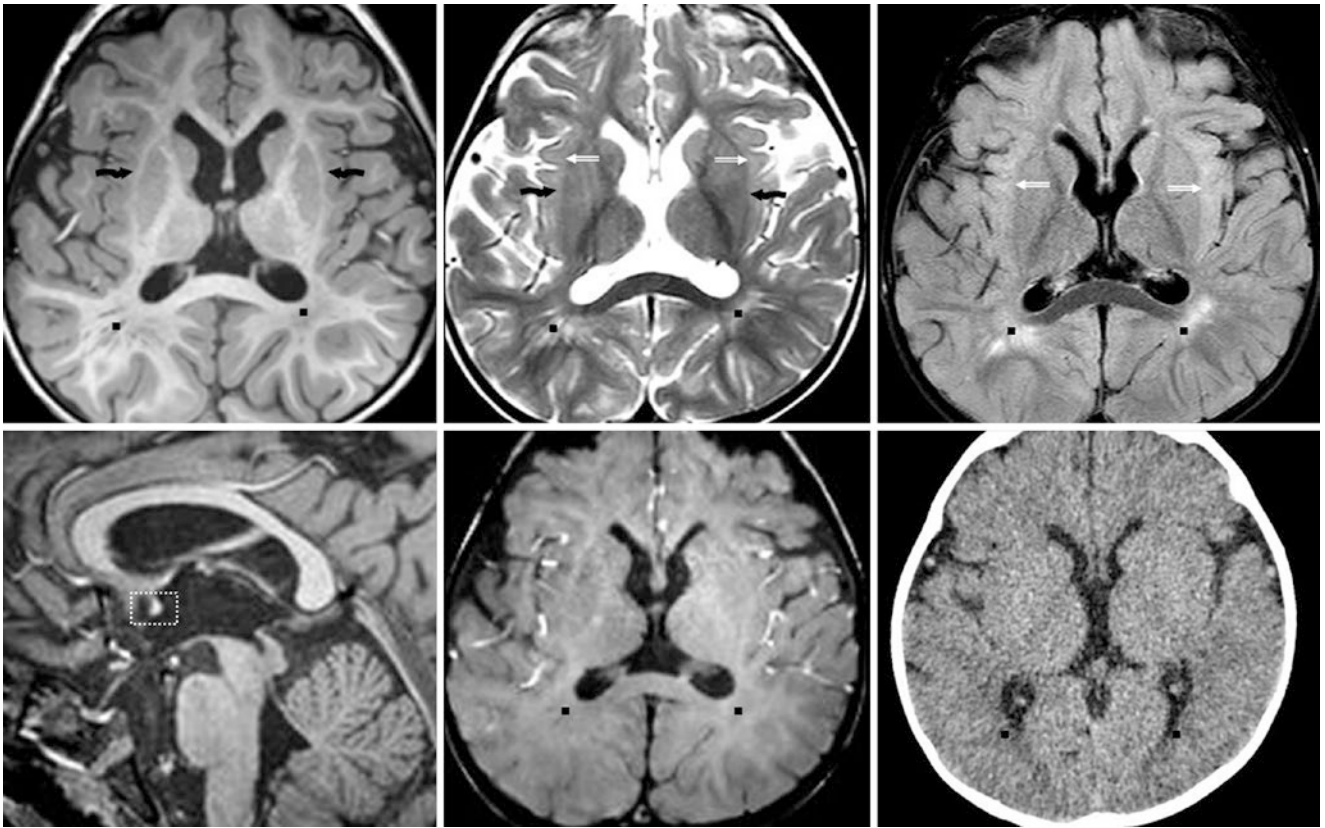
A developmentally normal 16-month-old with nausea had a normal 3T MRI. The EC (*crooked arrows*) appears mature on axial GE T1WI (*top left*) and SE T2WI (*top middle*). FLAIR (*top right*) shows mildly hyperintense subinsular terminal zones (*beveled arrows*).
